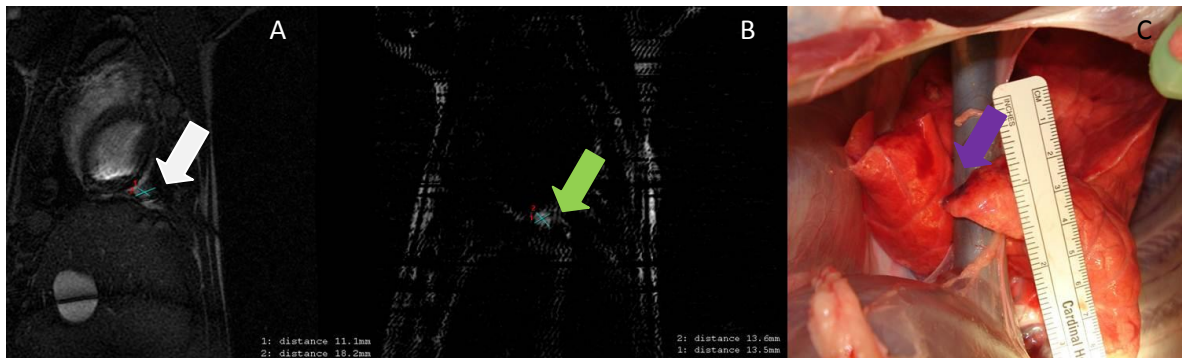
A: MR image (FIESTA) used for treatment planning in the pleura (white arrow) B: Post-ablation MRI (subtraction of LAVA images before and after ablation), showing a very small ablated area near the heart (green arrow); C: Necropsy image showing the ablated area in the pleura (purple arrow).
